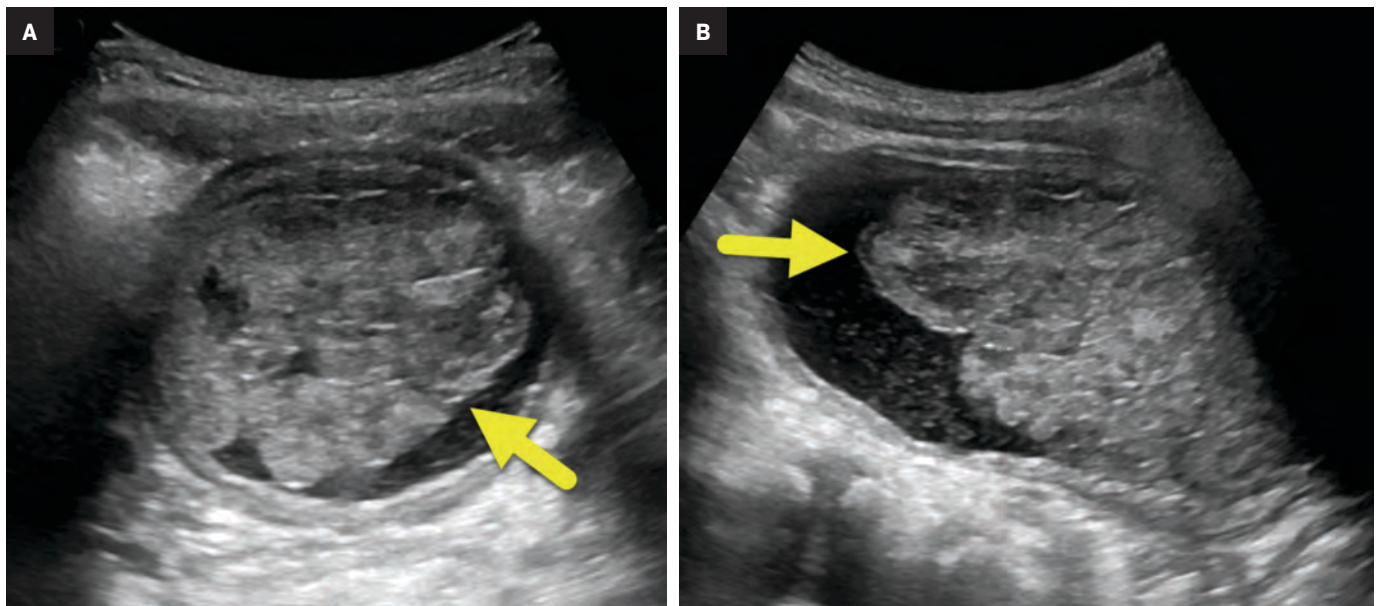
(A) Transverse and (B) longitudinal ultrasound of the bladder shows a lobulated mass (arrow) filling the bladder lumen. The urine has internal debris.
